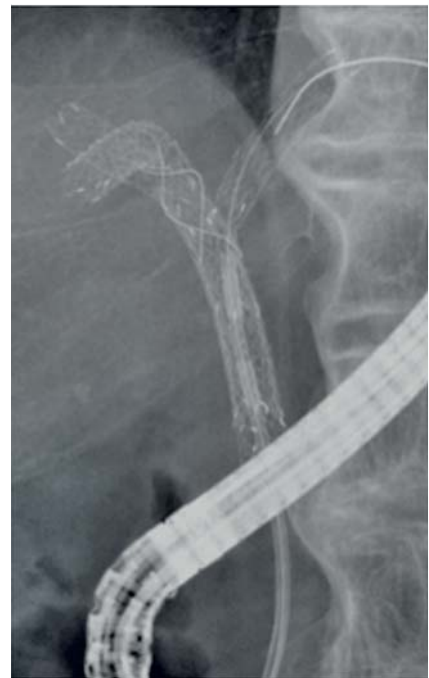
Radiographic view showing the radiofrequency ablation probe positioned in the bile duct.
